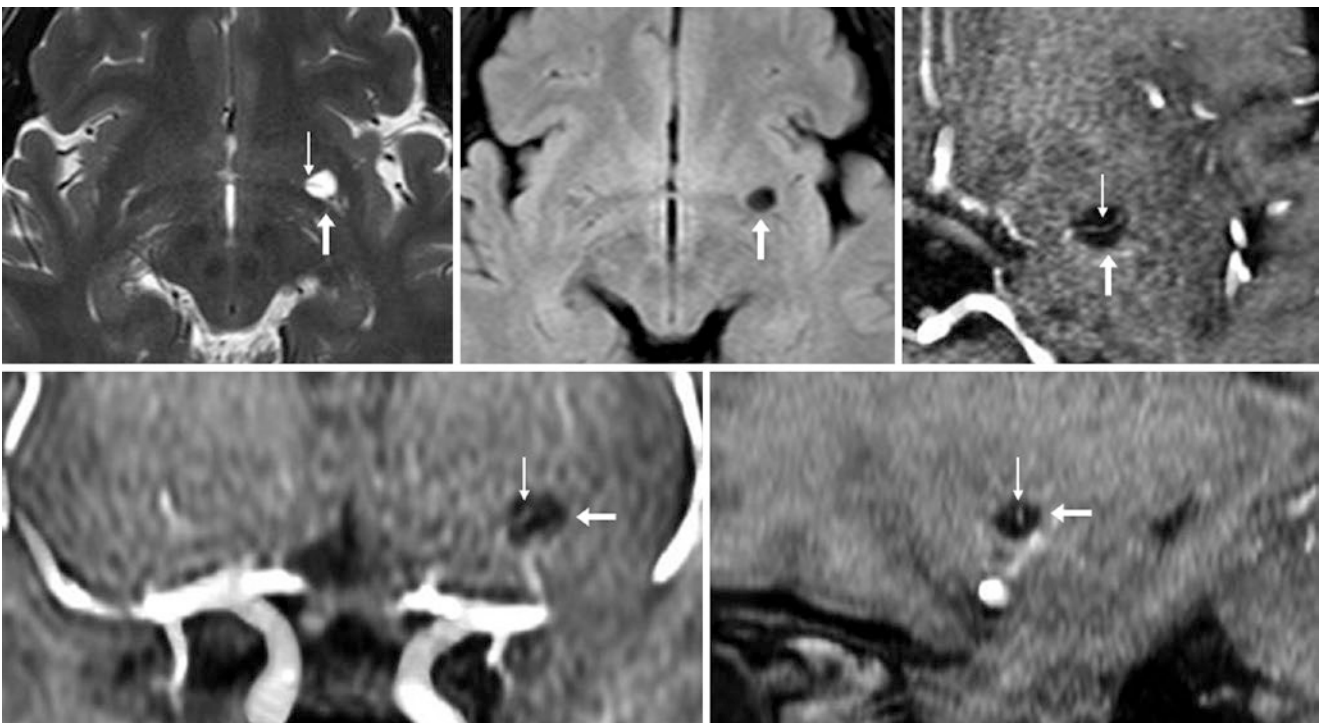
A 30 year old with an otherwise normal MRI had a dilated PVS (*arrows*) of the left inferior putamen on T2WI (*top left*), FLAIR (*top middle*), and magnified 3D time-of-flight (TOF) MRA reconstructions in axial (*top right*), coronal (*bottom left*), and sagittal (*bottom right*) planes. A small vessel (*tiny arrows*) traverses the PVS, arising from a lenticulostriate artery
